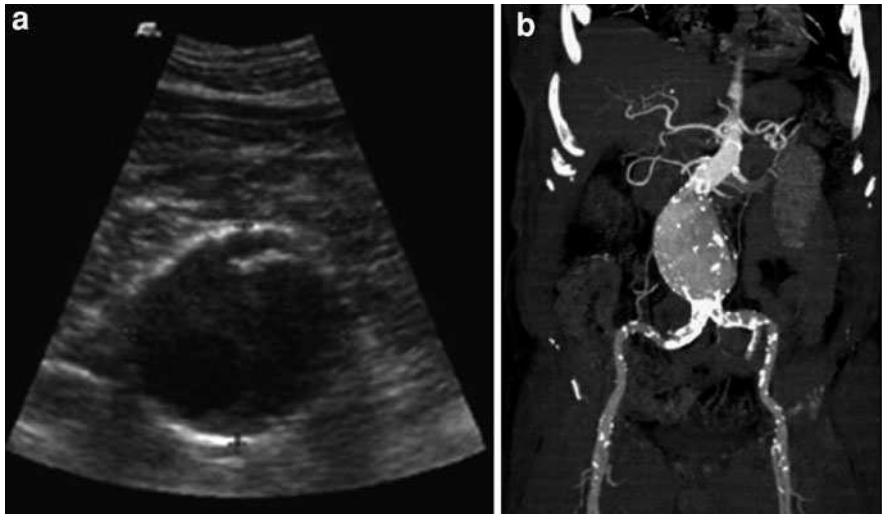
a Ultrasound image showing the patient’s 7.5 cm AAA and b CT image showing the infrarenal AAA from the anterior view
